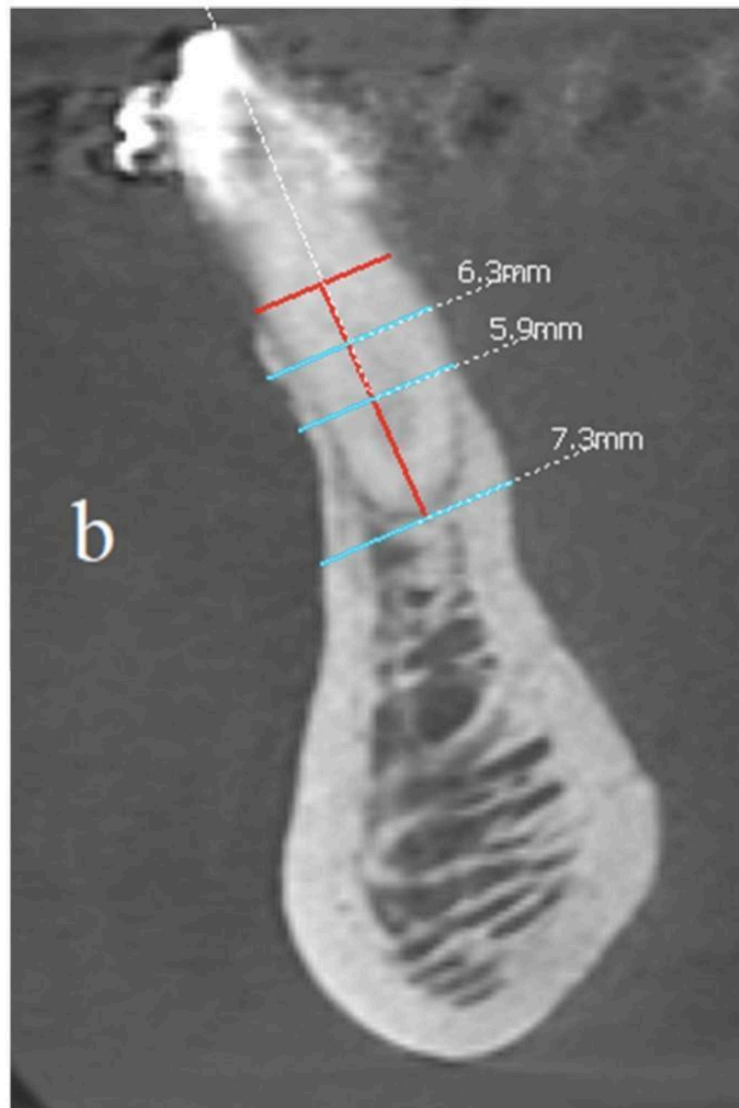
CBCT image two years after the surgical treatment—axial view.
